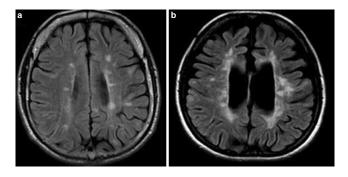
Looks can be deceiveing. The above images show axial plane brain MRI scans of two atypical PPMS patients who show multiple focal lesions in periventricular, deep and juxtacortical white matter more common in RRMS in addition to brain atrophy.
